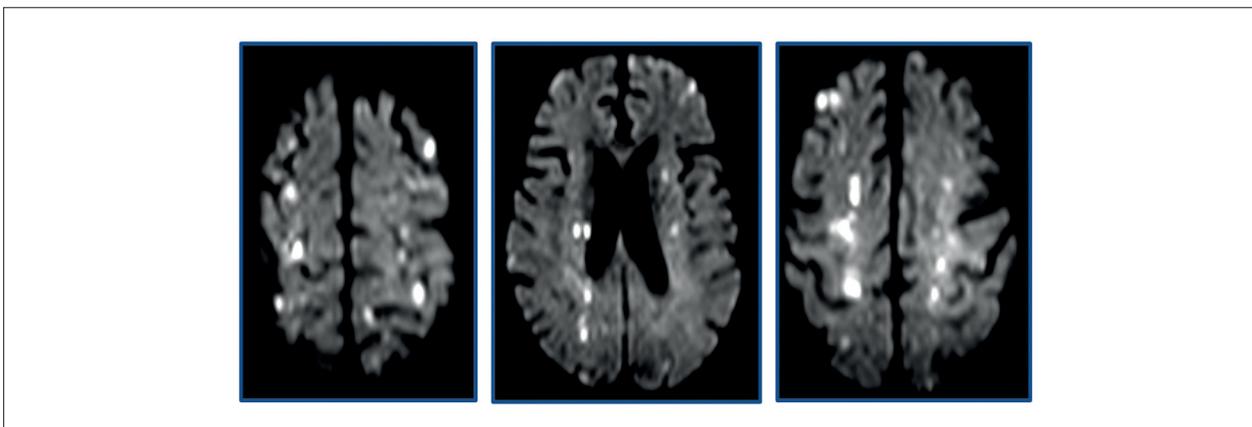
Nuclear MRI: Multiple cortico-subcortical hyperintense lesions on T2 and FLAIR sequences, with restricted diffusion, observed in both cerebral hemispheres. These lesions are distributed in border zone or watershed infarct territories.
